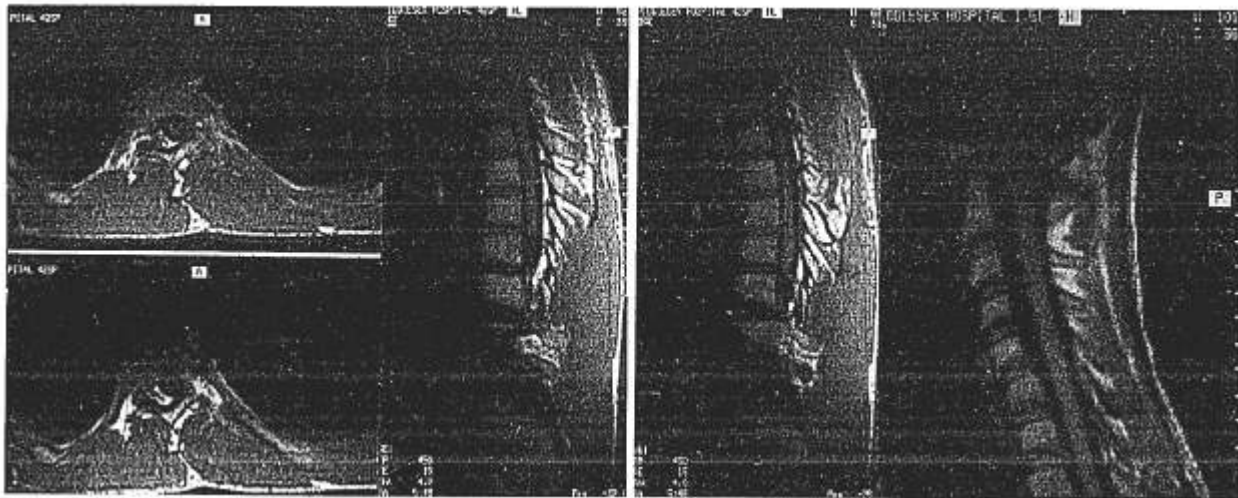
MRI imaging of thoracolumbar spine demonstrating a small syrinx at the T6–T8 vertebral levels, transverse section at the T7 vertebral level demonstrating the syrinx, and at the level of the foramen magnum, demonstrating the Chiari type I malformation.
